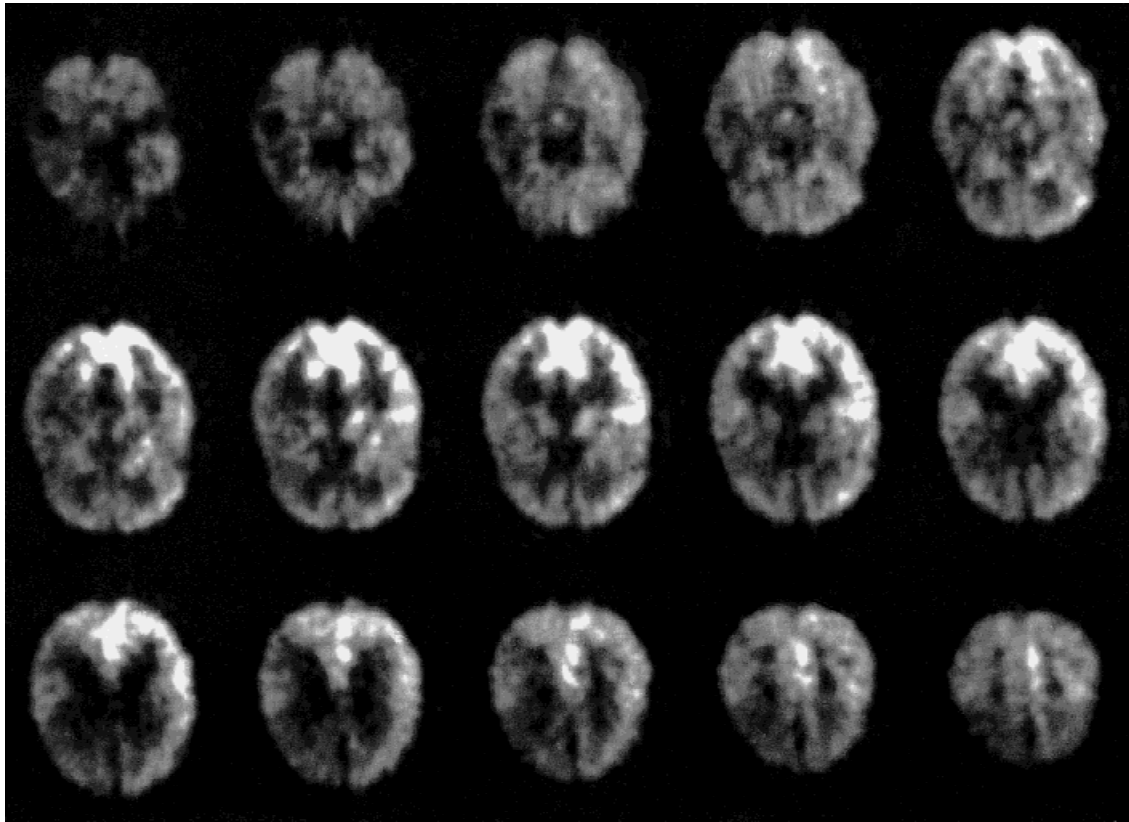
The fluorodeoxyglucose-positron emission tomography (FDG-PET) study showed a marked asymmetry with left frontoparietal and subcortical hypometabolism.
